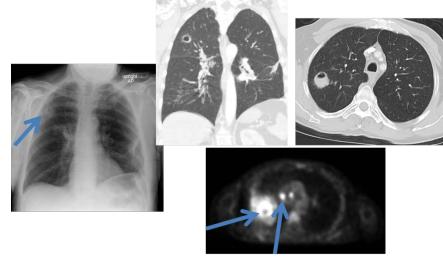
Squamous cell carcinoma. Frontal view of the chest demonstrates round lesion with lucency in the right upper lobe concerning for a cavitary tumor which is better seen on the coronal and axial views of the contrast enhanced CT of the chest. PET shows intense tracer uptake correlates with the right upper lobe cavitary lesion and is consistent with biopsy proven squamous cell carcinoma. Squamous cell carcinomas tend to cavitate. Notice 2 smaller areas of increased PET positivity consistent with hilar and mediastinal nodal disease. So this patient has T2a N2 disease by PET criteria. Image courtesy of the University of Massachusetts Medical School, Department of Radiology.
